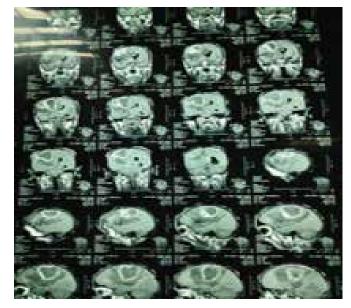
MRI brain showing contrast-enhancing cysts
